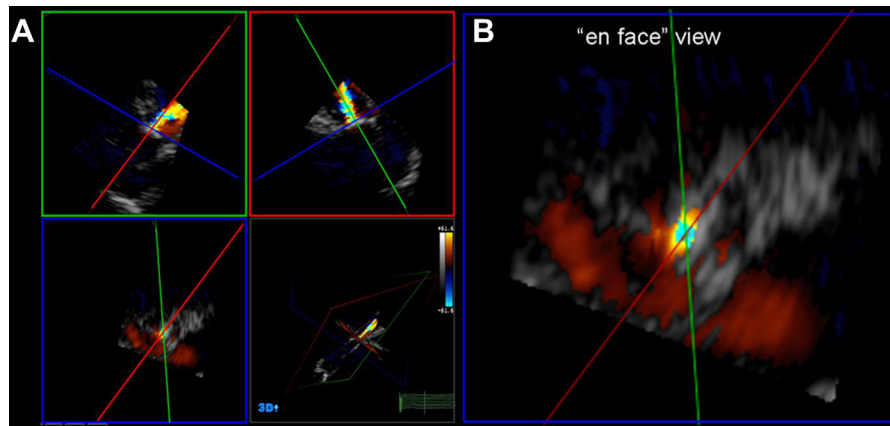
Three-dimensional transthoracic echocardiography for assessment of aortic EROA. First, the 3D color Doppler data set was manually cropped to provide a cross-sectional plane through the vena contracta of the regurgitant jet, perpendicular to the direction of the aortic regurgitant jet (A). Next, from the en face view of the vena contracta, selecting the plane with the narrowest cross-sectional area of the regurgitant jet, the 3D-EROA was measured by manual planimetry of the color Doppler signal (B). The figure provides an example of a patient with central and circular jet.
